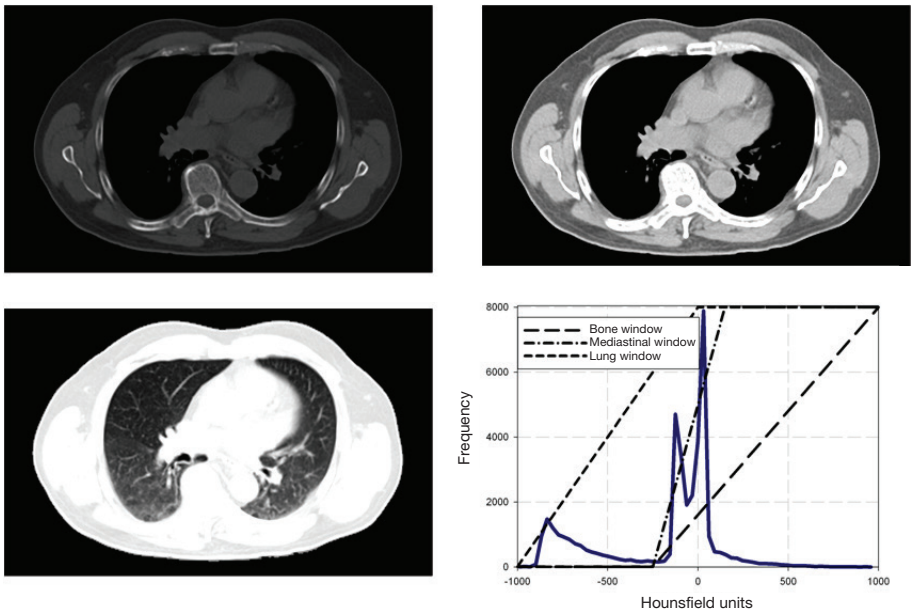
CT slice from Fig. 14.9 with typical lung and mediastinal windowing (upper row from left to right), a bone window (bottom left) and a histogram with corresponding linear window functions (bottom right).
